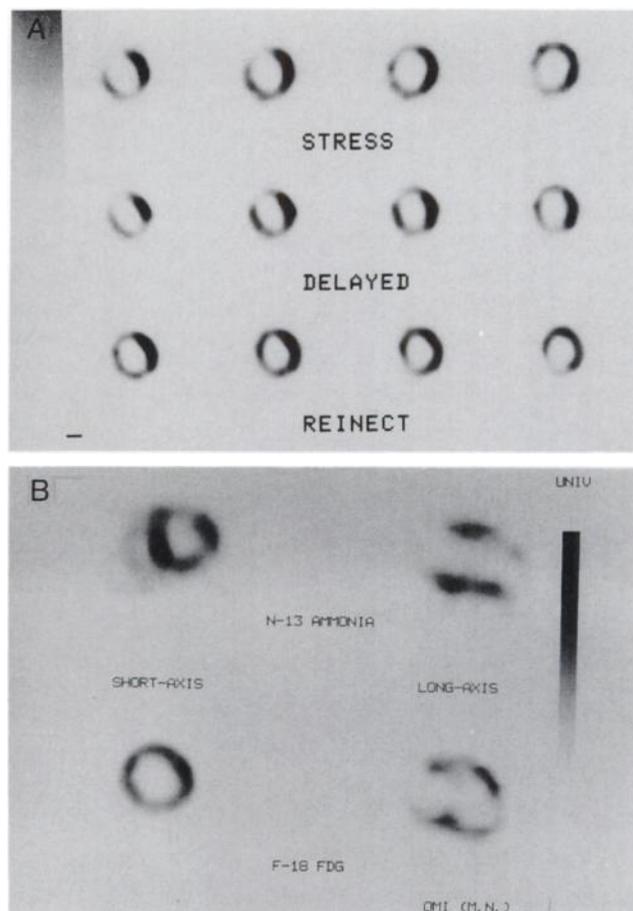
(A) A series of short-axis slices of stress (top), 3-hr delayed (middle), and reinjection (bottom) ^{201}Tl SPECT images of a patient with anterior wall myocardial infarction. Hypoperfusion in anterior, septal, and inferior regions is noted without definite redistribution on the delayed images, except slight redistribution in septal region. The reinjection images, however, show new fill-in in anterior and inferior regions. (B) Representative short-axis (left) and long-axis (right) slices of ^{13}N -ammonia perfusion (top) and FDG (bottom) images. Note hypoperfusion with increased uptake of FDG in anterior and inferior regions.
